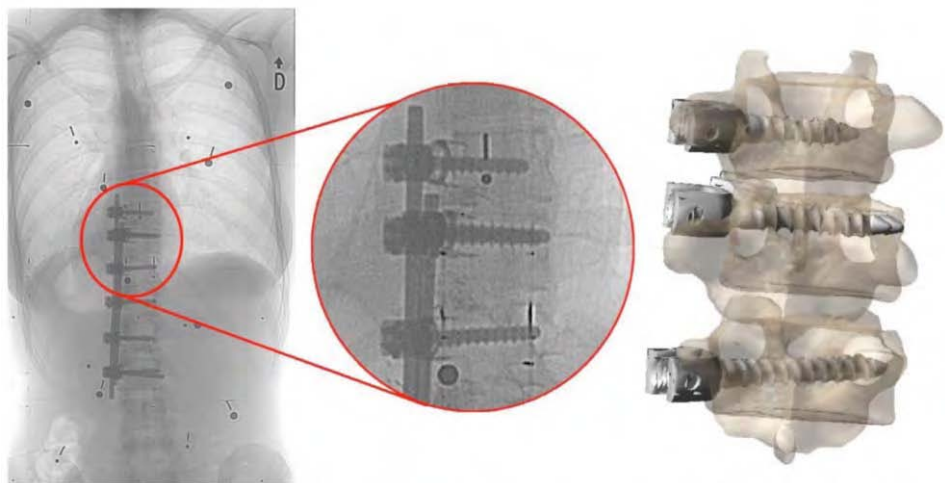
Position and orientation of the screws in the vertebral bodies viewed on the postoperative radiographs and in the biomechanical model prior to the attachment to the rod.
